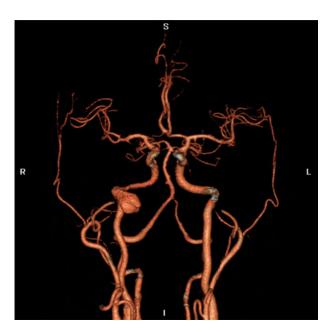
Computed tomography angiogram, demonstrating a right junctional cervical-petrous internal carotid artery pseudo-aneurysm. S=superior; R=right; L=left; I=infarior.
